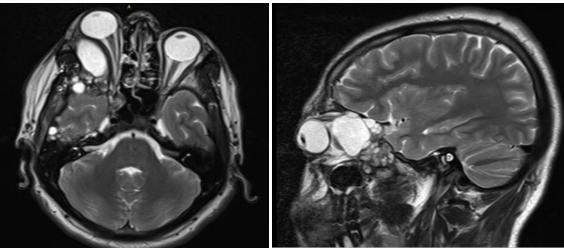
Axial and Sagittal T2 MRI images showing hyperintense cystic lesion extending from the eroded mandibular fossa into the right orbit, compressing the globe and optic nerve with proptosis.
